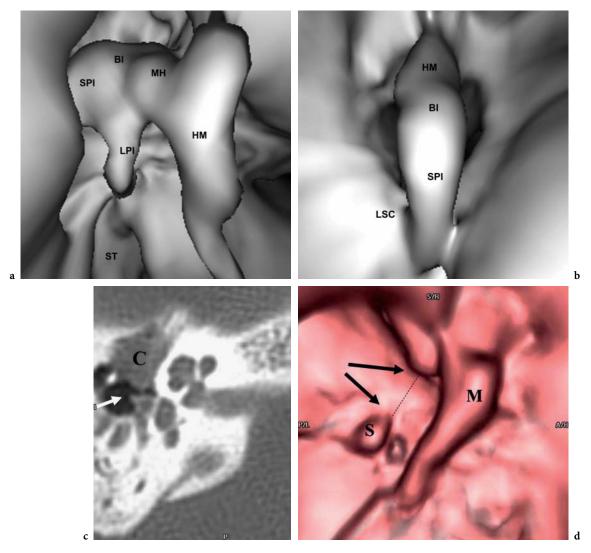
Virtual endoscopy of the ossicular chain. a Lateral view including almost the entire ossicular chain: HM, handle of malleus; MH, malleus head; BI, body of incus; SPI, short process of incus; LPI, long process of incus, ST, sinus tympani. b Superior view of the incudomalleolar joint. The eminence of the lateral semicircular canal (LSC) represents an important surgical landmark for mastoidectomy. c Axial CT study in a patient with right colesteatoma (C), that shows the absence of the lenticular process of the incus. d Endoluminal view of the middle ear demonstrates the absence of the lenticular process of the incus. M, malleus; S, stapes
